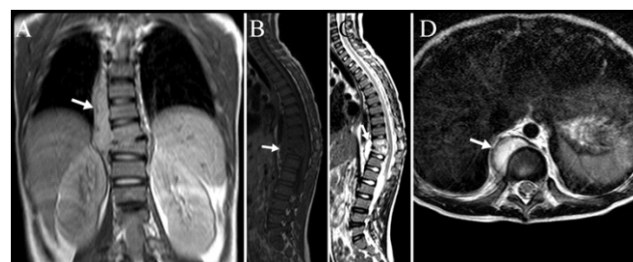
A 6 years old girl with spine TB. Images from MRI (T1, A-B and T2, C-D) showing destructive segments located at T10-T11 vertebrae and showing paravertebral collection extending from T7-T11 (arrow).
